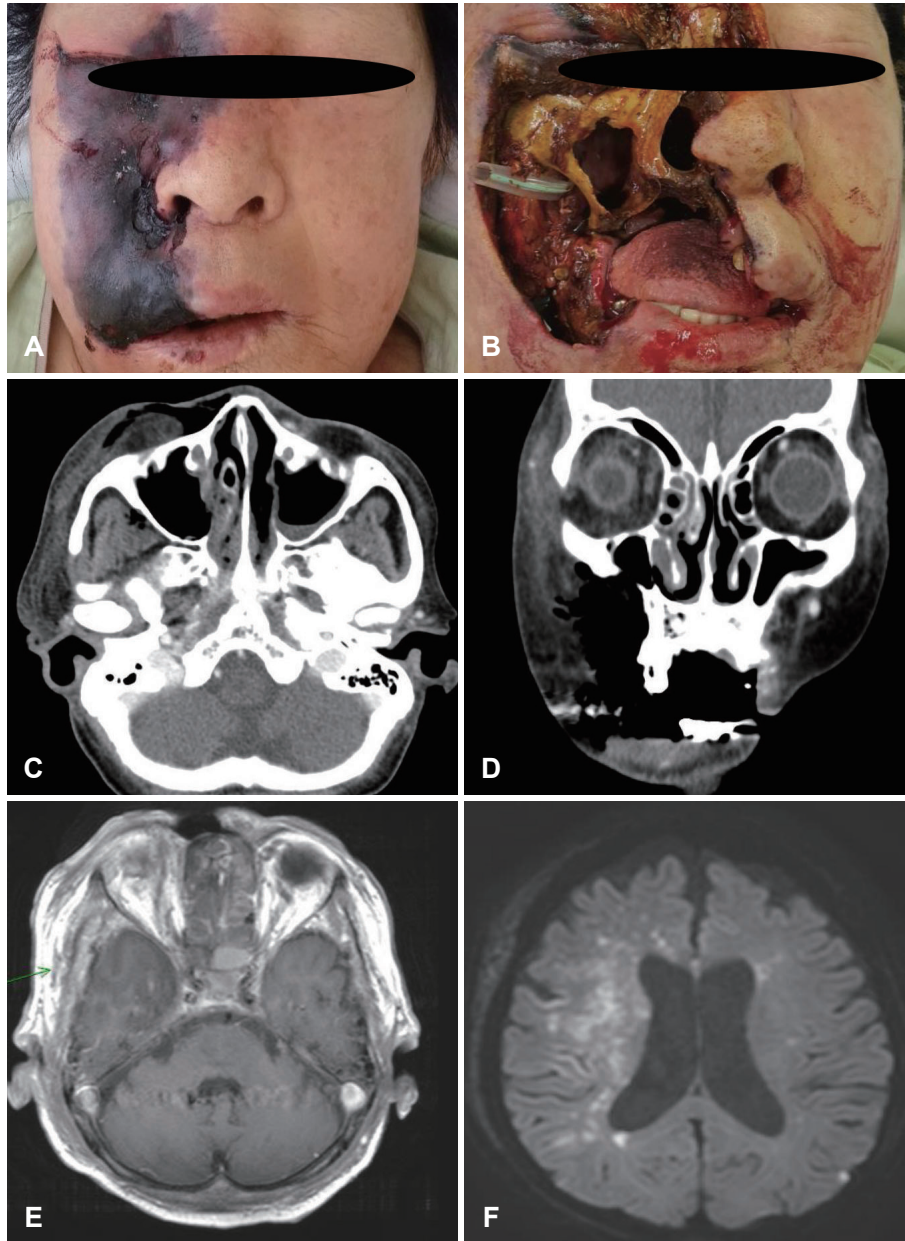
Facial photo and radiologic images of the patient. A: The initial physical examination shows blackish eschars on the right side of the face. B: Extensive debridement was performed, including the facial skin, maxillary bone, and nasal mucosa. C and D: Preoperative axial (C) and coronal (D) contrast-enhanced CT scans showed cellulitis with air formation without any definitive abscess. E: T1-weighted contrast-enhanced MRI revealed involvement of the cavernous sinus and internal carotid artery by infection. F: Diffusion-weighted imaging showed multifocal acute ischemic lesions on the right middle cerebral artery territory and the left corona radiata.
